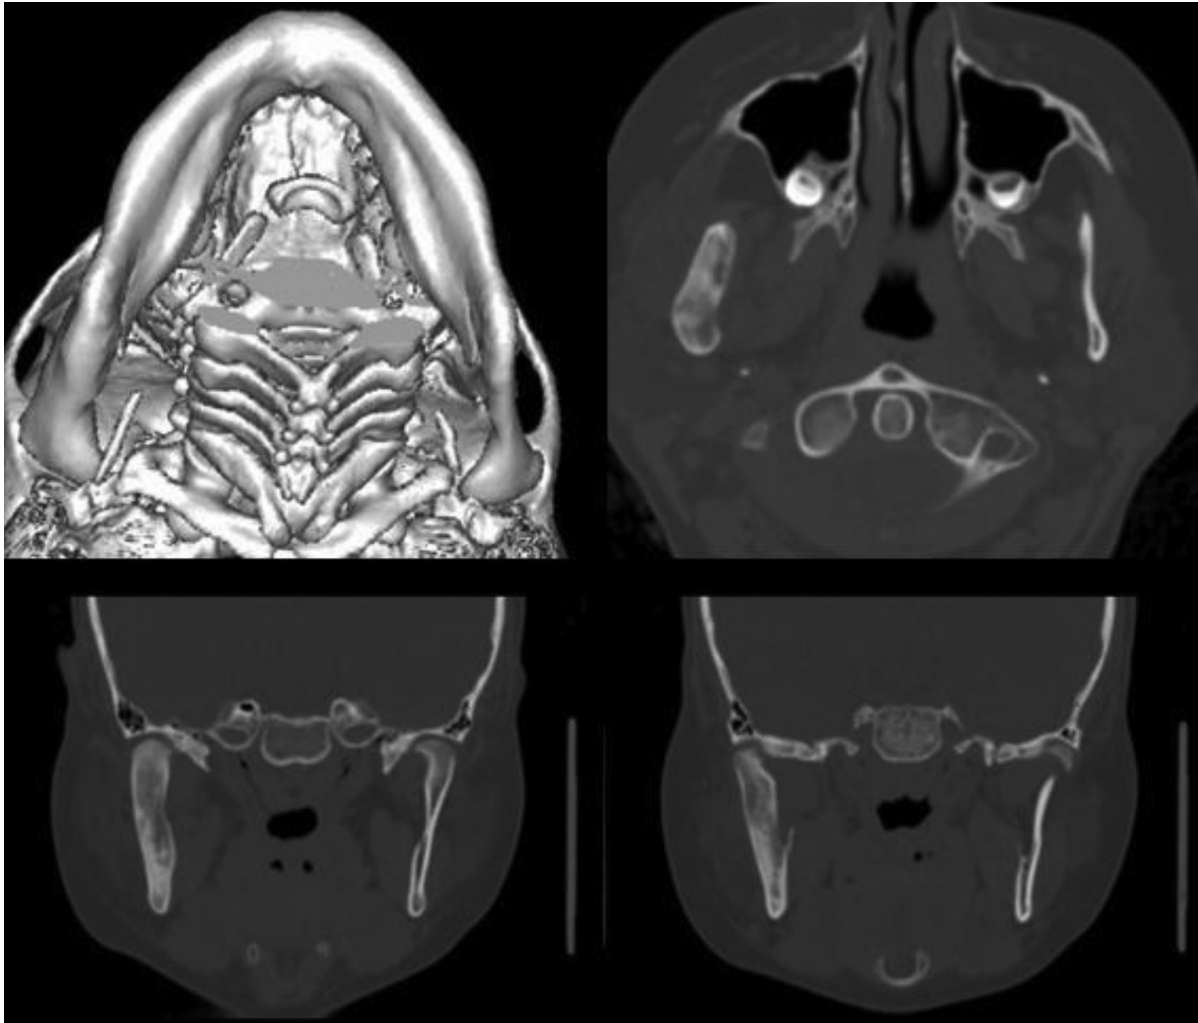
3D reconstruction of the affected right ramus shows stable deformation with no additional increase in volume. CT axial images and coronal MIP reconstructions demonstrate a more homogenous appearance of the “ground-glass” view with sclerotic surroundings, less “lytic” lesions
